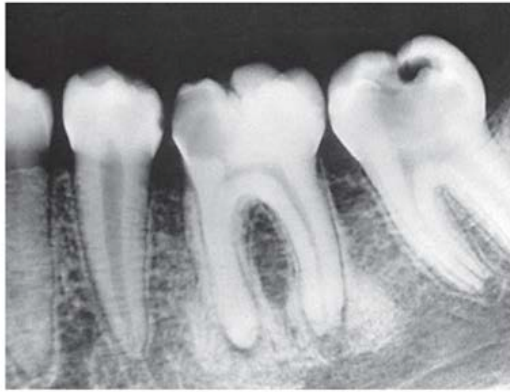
Periapical sclerosing osteitis associated with the first molar. This is called a sclerosing lesion because most of the lesion is bone formation, resulting in a very radiopaque density. Note, however, the small region of bone loss next to the root apex and the widening of the periodontal membrane space.
